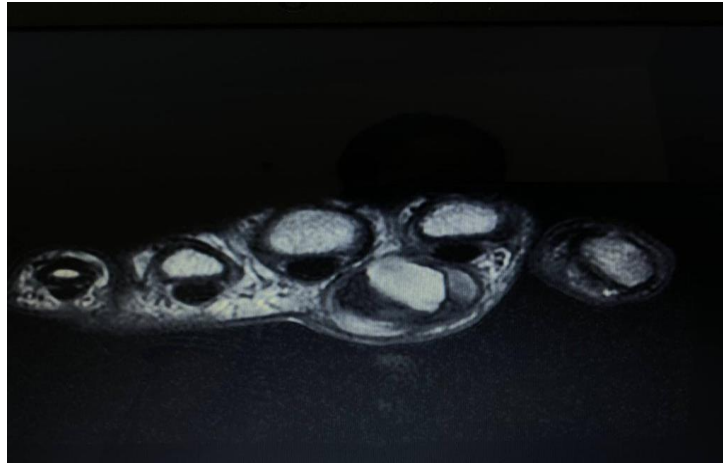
T1 Weighted MRI Image of Left Hand (Axial Section)
